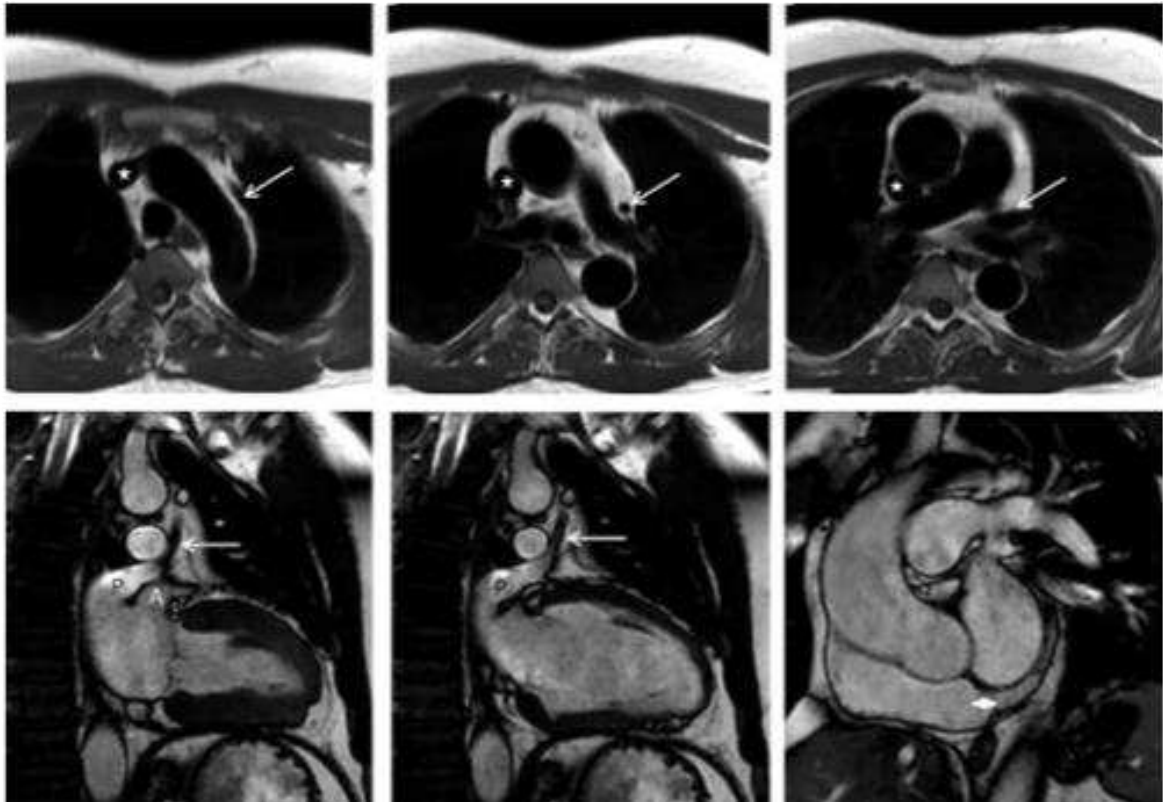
PLSVC seen by Cardiac MRI in Axial T1(63)
